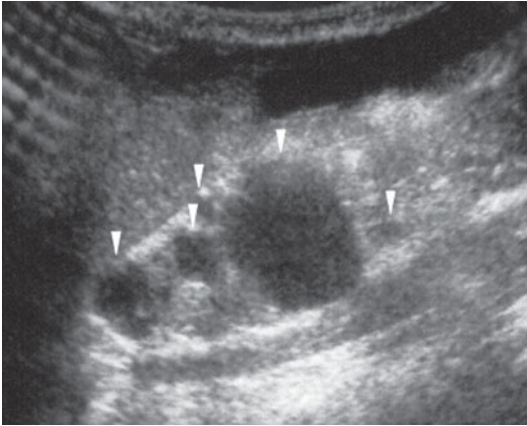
Multicystic kidney. Longitudinal sonogram shows several formations with cystic appearance (*arrowheads*) in the thinned renal parenchyma
